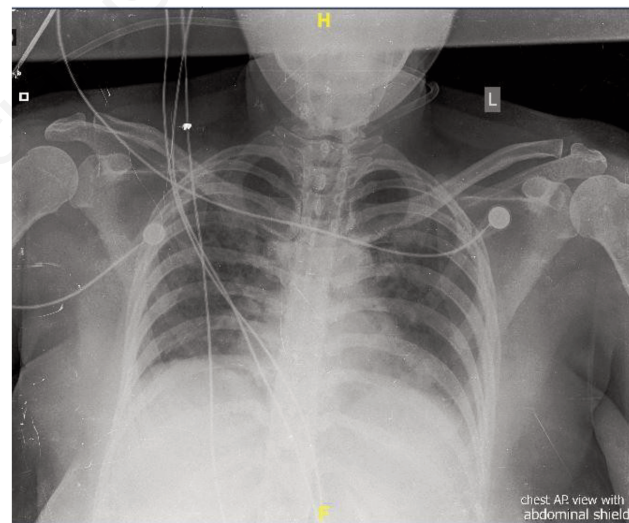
Chest X-ray AP view showing reticulations and nodules in all areas.
